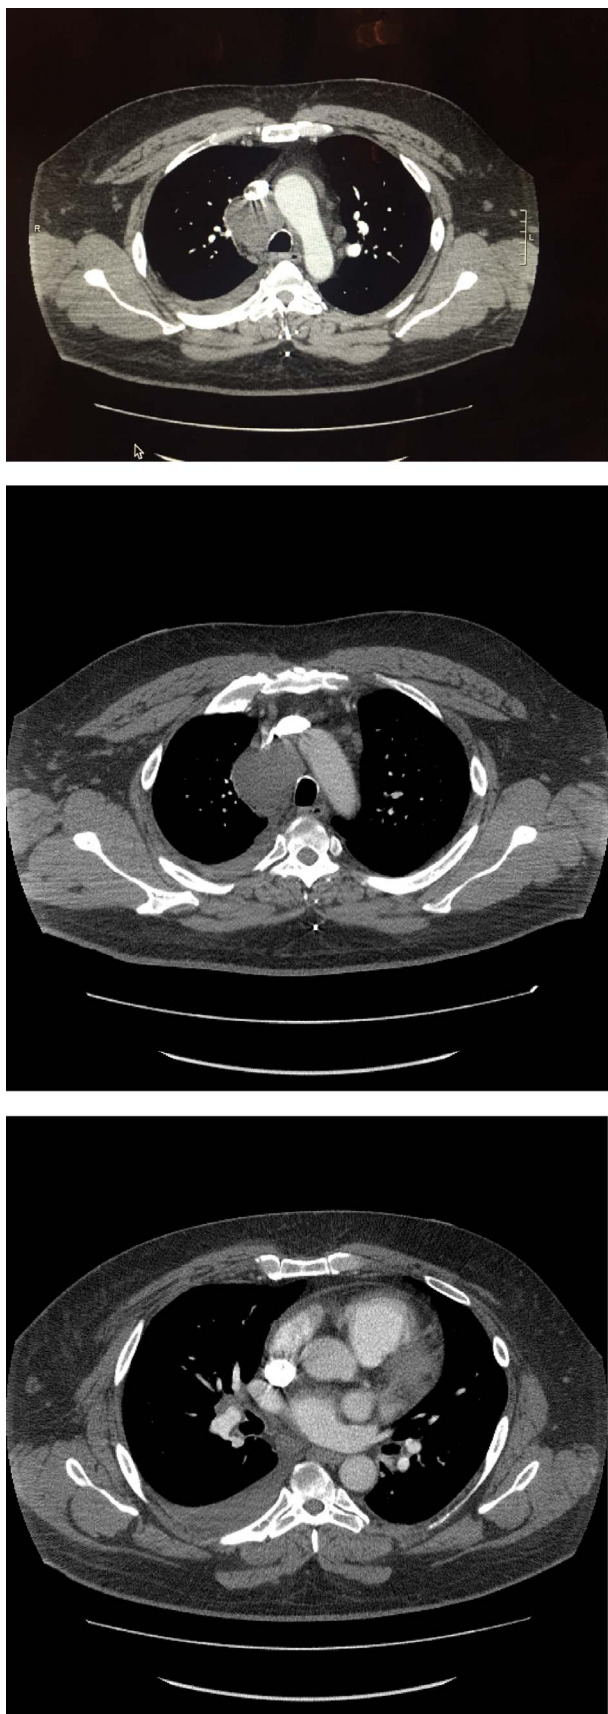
CT scan showing a paratracheal mass with hilar adenopathy and a pleural effusion.
